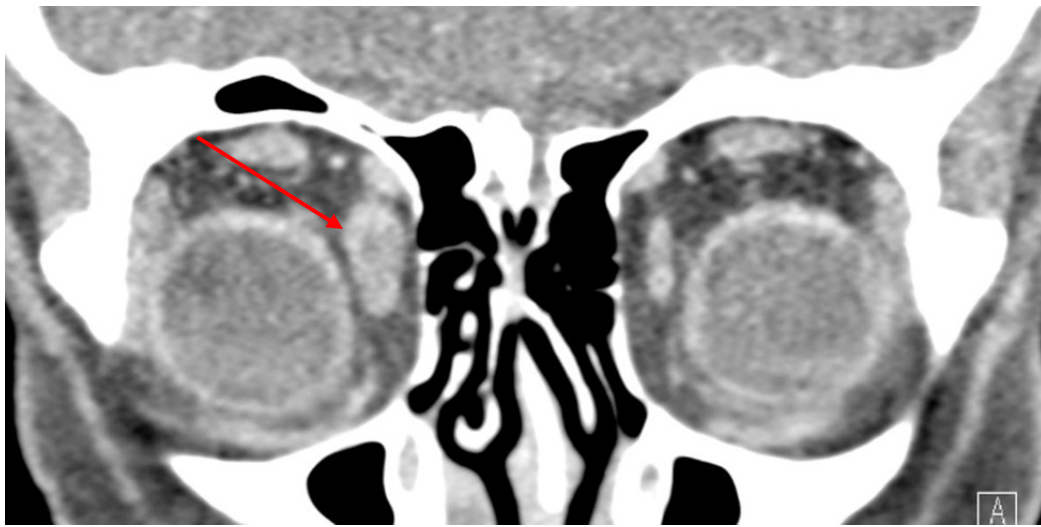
Orbital CT, coronal. Asymmetric enlargement of the medial rectus in the right orbit (red arrow).
